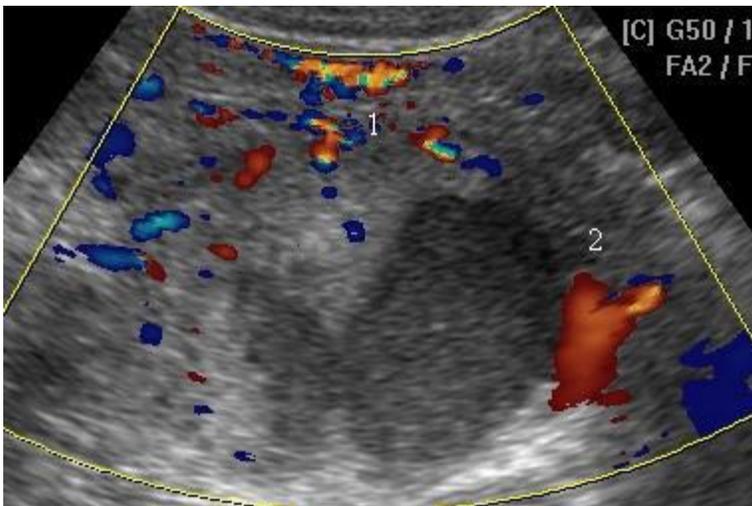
Transabdominal ultrasound mode DRC: 1 — vessels of the tail of the pancreas pushed anterior cystic formation; 2 — "vascular pedicle" of formation.
